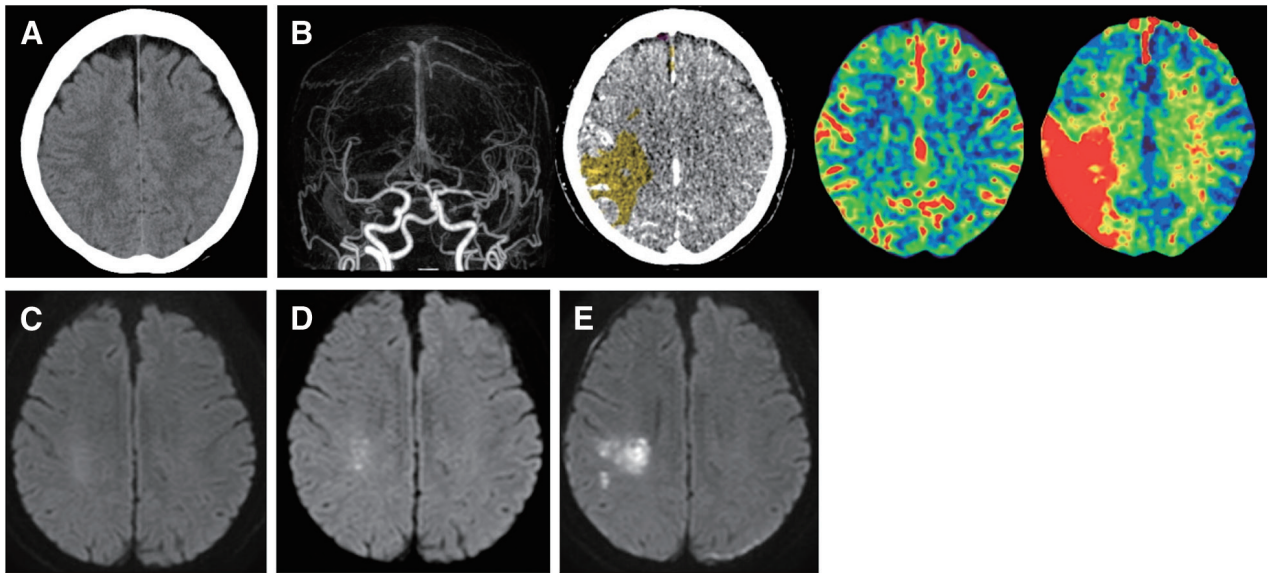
A 73-year-old woman presented with a chief complaint of dysrhythmia. (A) CT scan of the head showing no obvious abnormal findings. (B) CTA on arrival showing occlusion of M3 in the right middle cerebral artery, CTP in the head, and suspected ischemic changes in the right parietal lobe, with decreased CBV and CBF and prolonged TTP and MTT. The penumbra to core ratio (P/C) value was 59.84.
